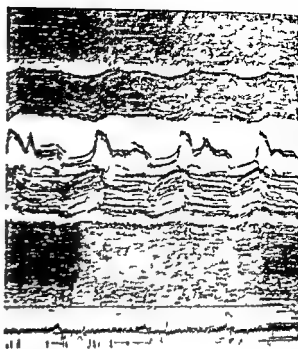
The echocardiogram shows marked thickening of the interventricular septum and the posterior left ventricular wall with diminution in the diameter of the left ventricular cavity. There is a small posterior pericardial effusion.
